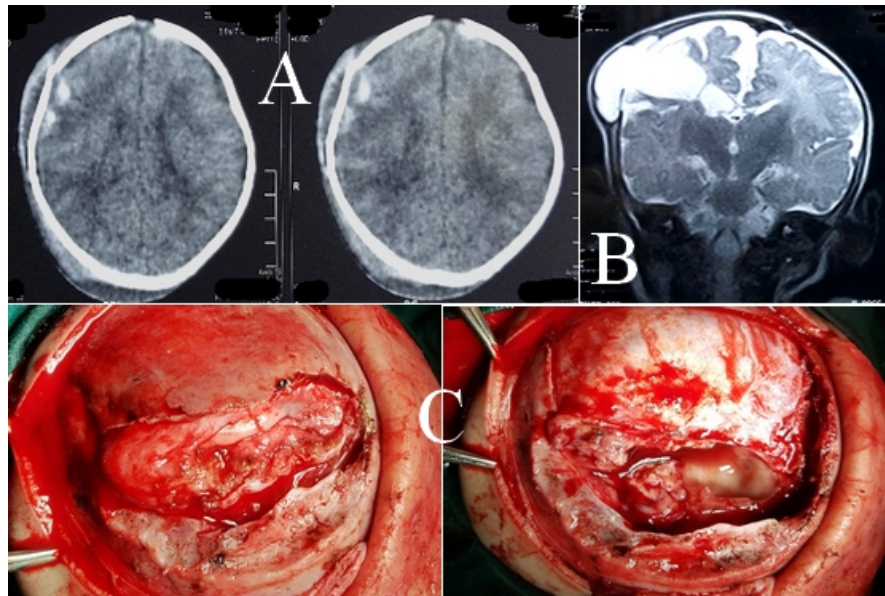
A three years old male patient, presented with domestic head trauma, A: initial CT showing fissure fracture with underlying cerebral contusion, B: MRI follow up after 6 weeks showing herniation of dura and CSF sac through a widened fissure, C: intra-operative images of dural repair showing extension of the defect into the ventricle.
